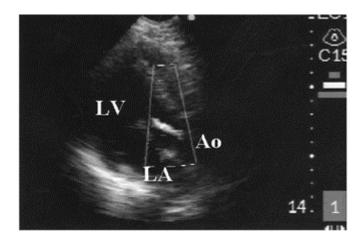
Mild aortic regurgitation depicted by directional color power Doppler system. Ao: aorta; LA: left atrium; LV: left ventricle.
